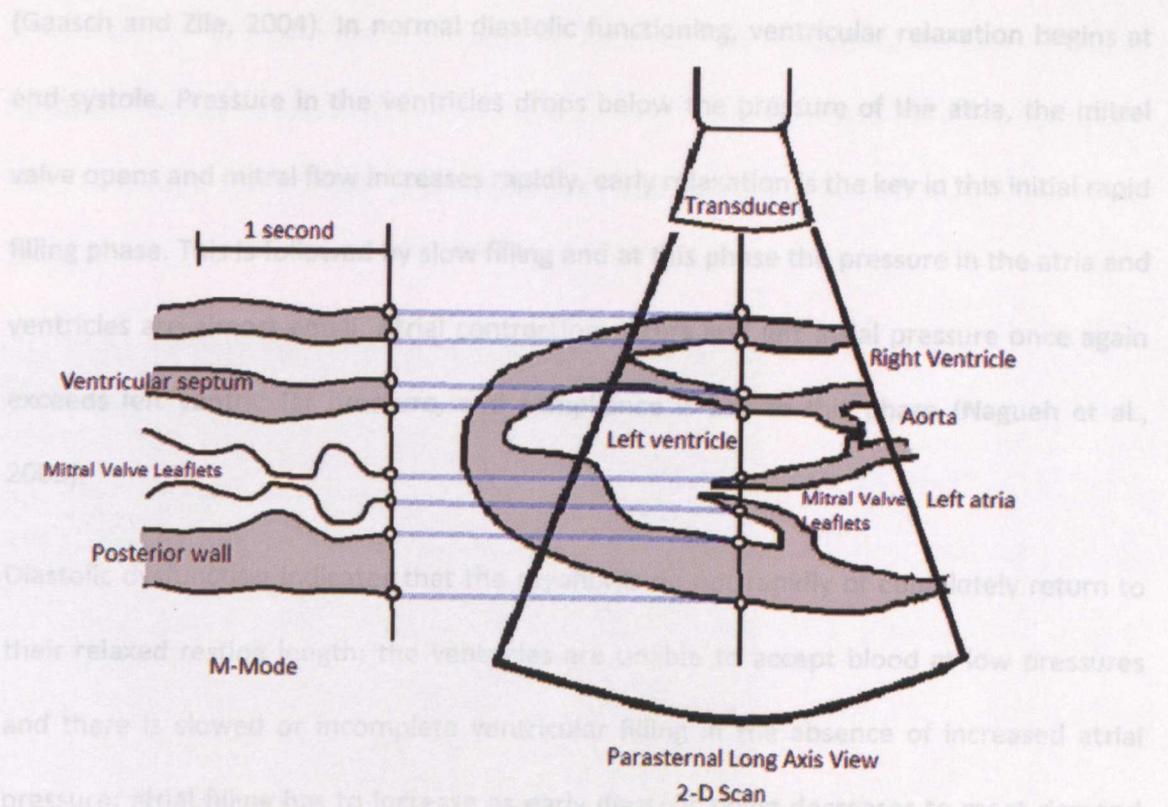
2D Image of assessing LV Mass in parasternal long axis view. Drawn by author.
